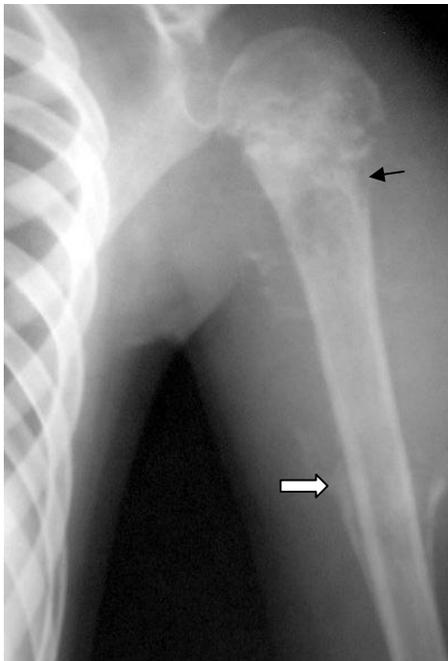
Enlargement radiograph of the humeral bone in a direct projection. In proximal metaphysis area of the humerus there are extensive sites of destruction with indistinct contours and destruction of the cortical layer (arrow). There are periosteal reaction in the upper third of the diaphysis – Codman's triangle (a figured arrow). Osteogenic sarcoma of the humeral bone.
